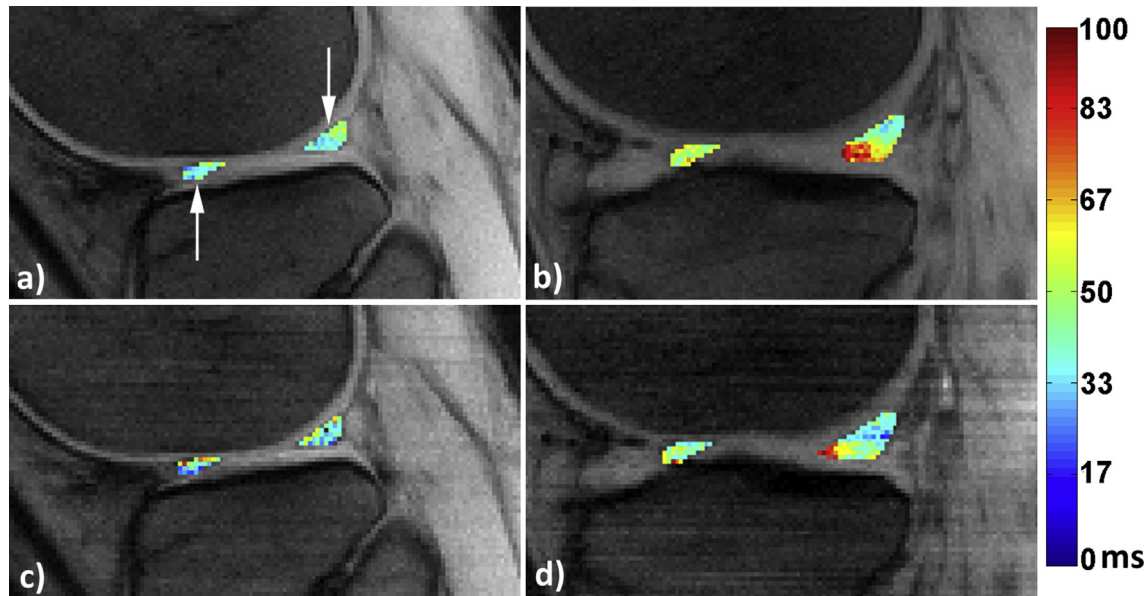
Representative sagittal MR images showing adiabatic $T_{1\rho}$ (a, b) and adiabatic $T_{2\rho}$ (c, d) relaxation time map of the lateral menisci in asymptomatic subjects (a, c) (age 52, female), and patient with mild OA (b, d) (age 50, male, KL = 2). AHLAT (arrow pointing upward) and PHLAT (arrow pointing downward) correspond to anterior horn and posterior horn of the lateral meniscus respectively. Prolonged relaxation times in the patient's PHLAT ROIs as shown by the colormaps can clearly differentiate the meniscal matrix of the patient from the asymptomatic subject.
